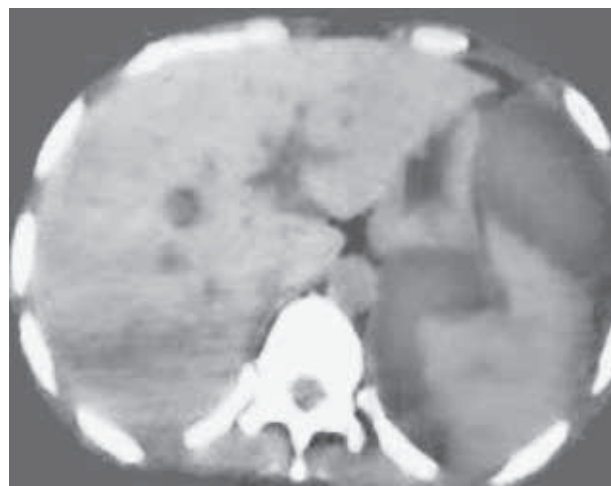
Damage to the spleen (CT)
